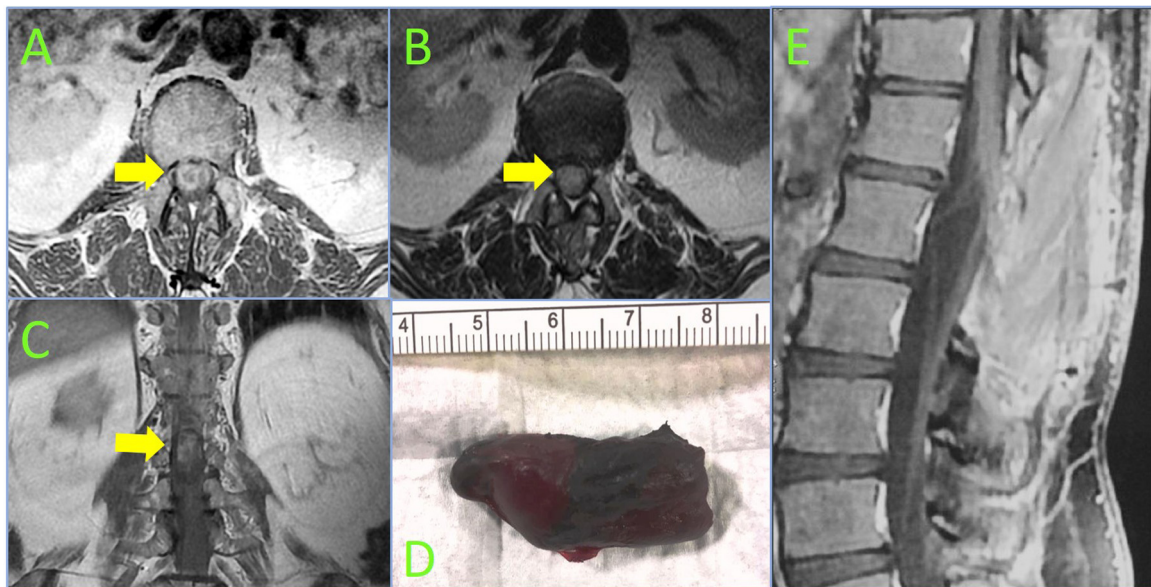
Axial T1 (A) and T2-weighted (B) and coronal T1-weighted (C) images showing a large lesion (yellow arrow) taking up the vast majority of the cross-sectional area at L1-L2 level, obscuring the visibility of the cauda equina. Photograph of the hemorrhagic paraganglioma (4 × 2 cm) after excision en bloc (D). One year post-operative, sagittal T1-weighted image after gadolinim (E) demonstrating no residual or recurrent contrast enhancing tumor.
